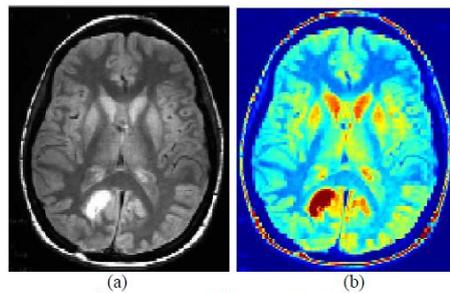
Clustering approach for MRI Scans
